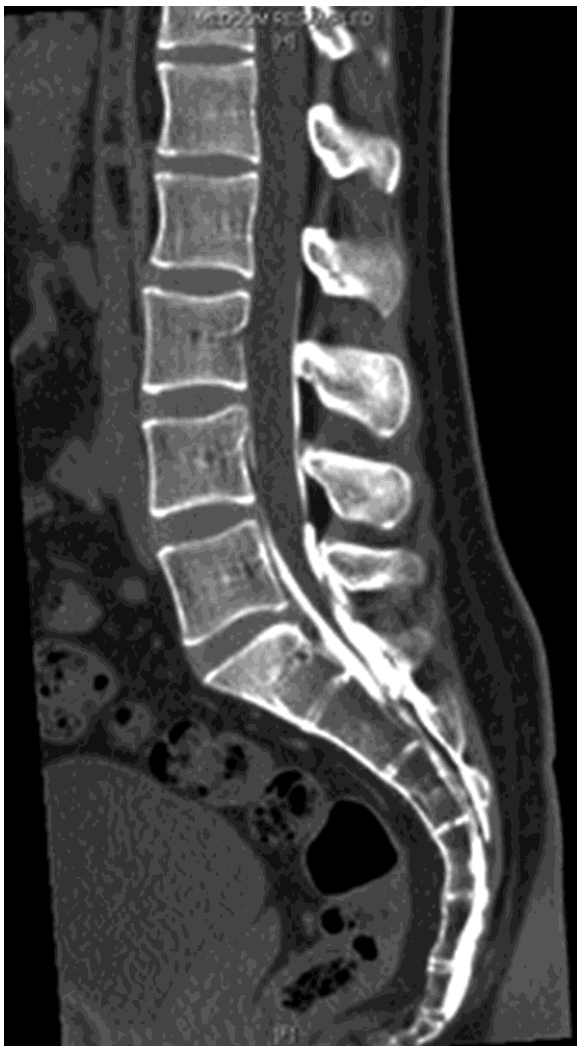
Example of sacral hiatus corticosteroid injection with contrast solution; CT scan taken after the procedure (sagittal midline slice) showing diffusion toward the L2-L3 disc.
